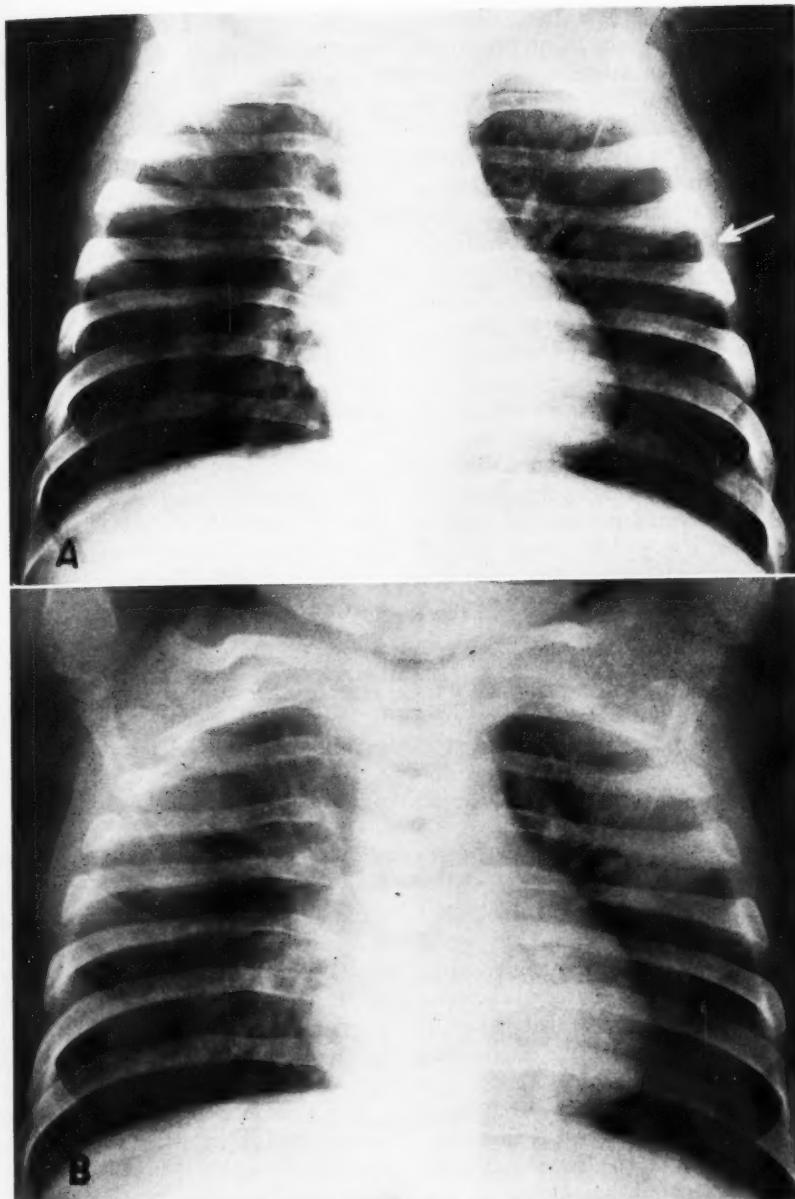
Anteroposterior chest roentgenogram taken at admission twenty-four hours before death. The findings are less impressive than seen at autopsy. Note intercostal bulging on right (arrows).
